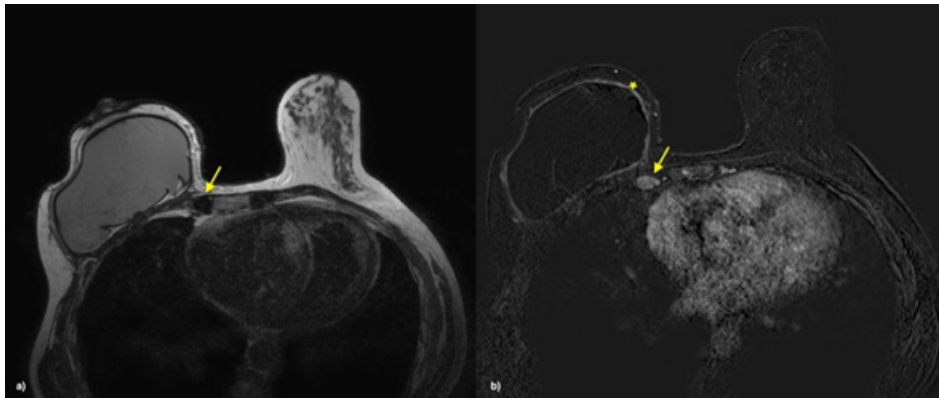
A 46-year-old woman with a history of right-sided breast cancer with reconstruction with breast implant. The MRI study revealed the presence of adenomegaly in the right internal mammary chain (arrow), evidenced in the weighted sequence in T2 (a) and T1 after contrast (b). Concomitantly, there is an early and diffuse enhancement of the fibrous capsule (asterisk), in a probable relation with the underlying inflammatory process, thus explaining the reactive nature of the identified adenomegaly.
